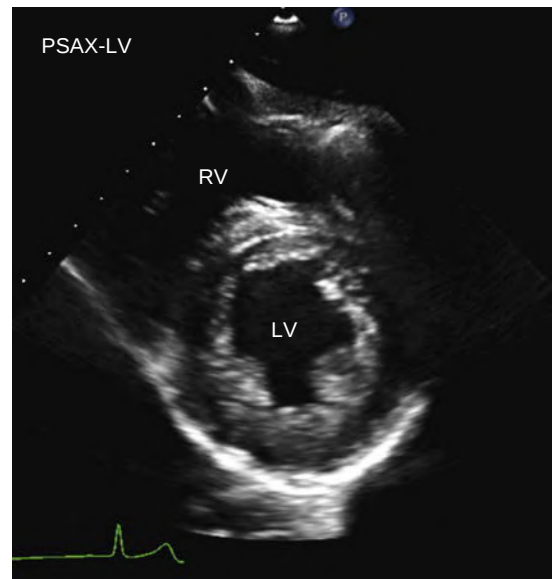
LV short-axis view. Parasternal short-axis (*PSAX*) view of the LV at the papillary muscle level. The LV cavity should appear circular in this view, and an elliptical shape suggests an oblique intercept angle. This view sometimes requires the transducer be moved slightly apically from the short-axis view of the aortic valve, instead of just tilting the transducer toward the apex from a fixed position on the chest wall.
